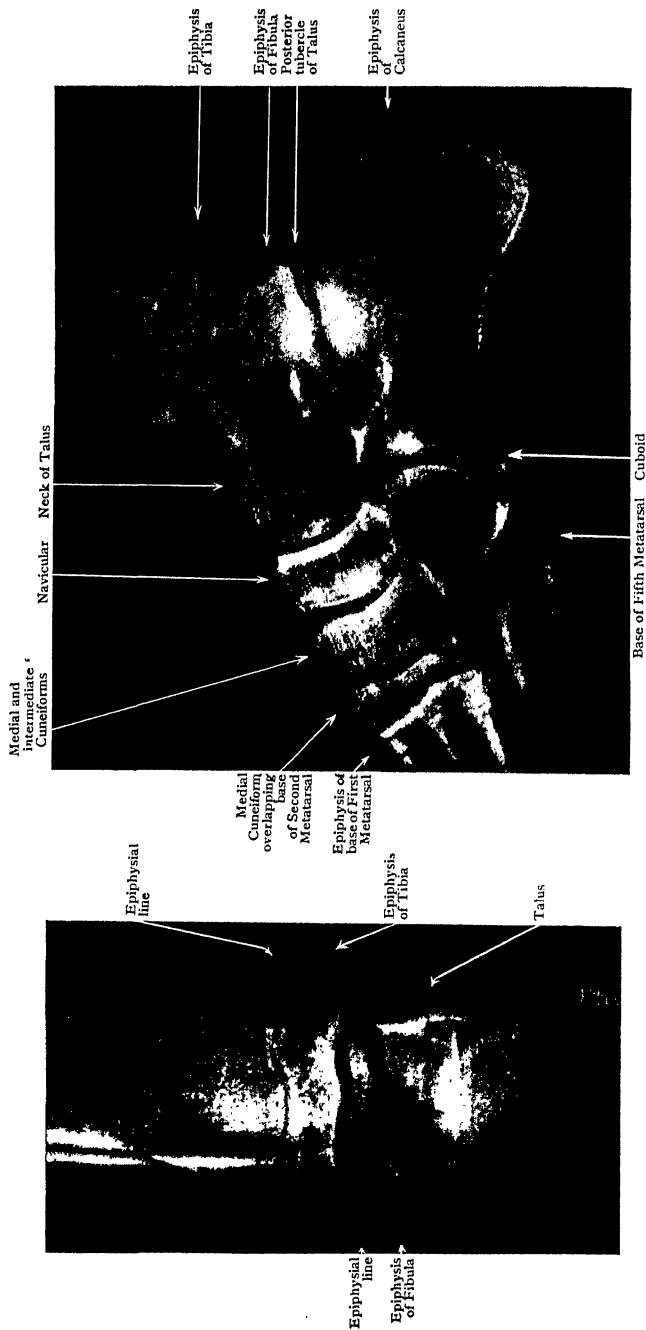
Antero-posterior Radiograph of Ankle of girl aged 12.
